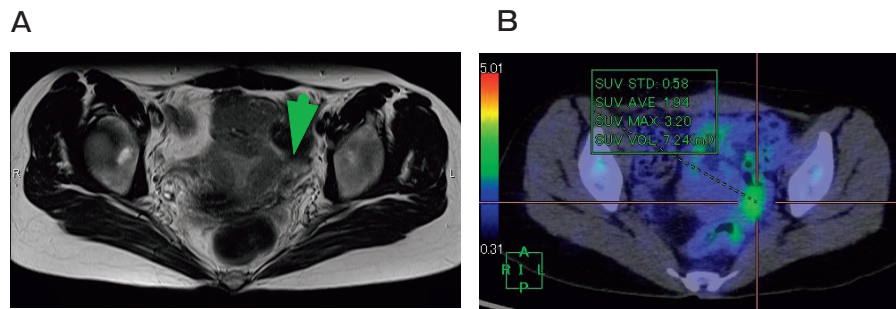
After 6 courses of chemotherapy, the tumor of the left pelvis had become smaller but still remained (A); positron emission tomography (PET)-CT revealed the uptake of fluorodeoxyglucose (SUVmax = 3.20) (B).
